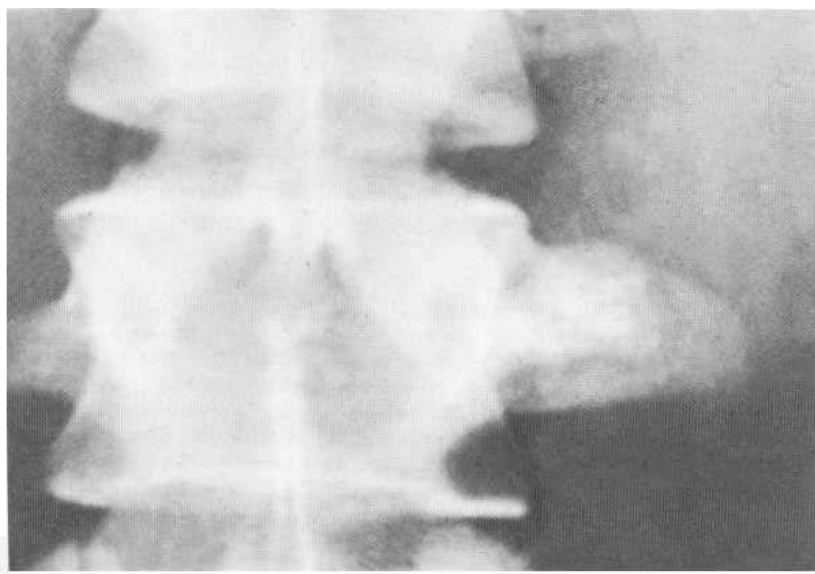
Osteoblastoma of the left transverse process of L3. (A) In this example the central area exhibits calcification. Expansion is present with diffuse sclerosis. (B) Note on the bone scan (which has been reversed for ease of comparison) the extensive area of increased activity corresponding to the whole of the osteoblastoma on the plain film. Note also the scoliosis, with which these patients may present.
